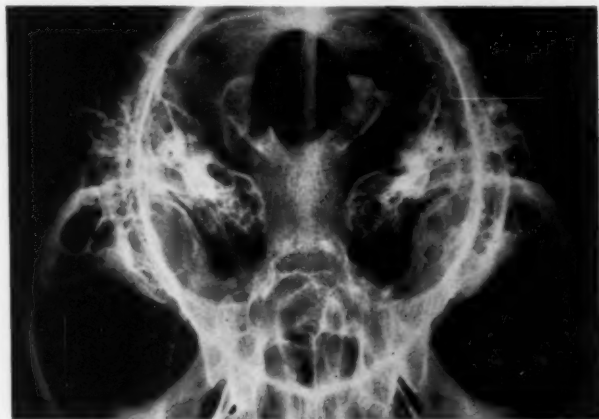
Slightly reduced basal view Roentgenogram of adult Orang, showing well pneumatized temporal bones.
